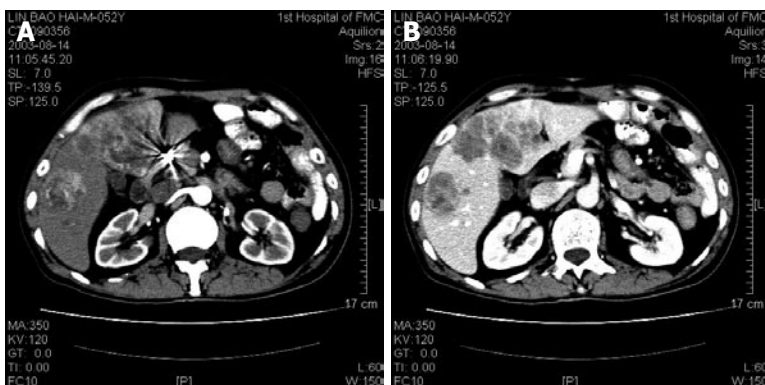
CT imaging features of liver metastatic tumor. A: CT scan revealing nodular or lump-like, high-density contrast mass in liver lobes during arterial phase; B: Uneven enhancement during portal venous phase.
